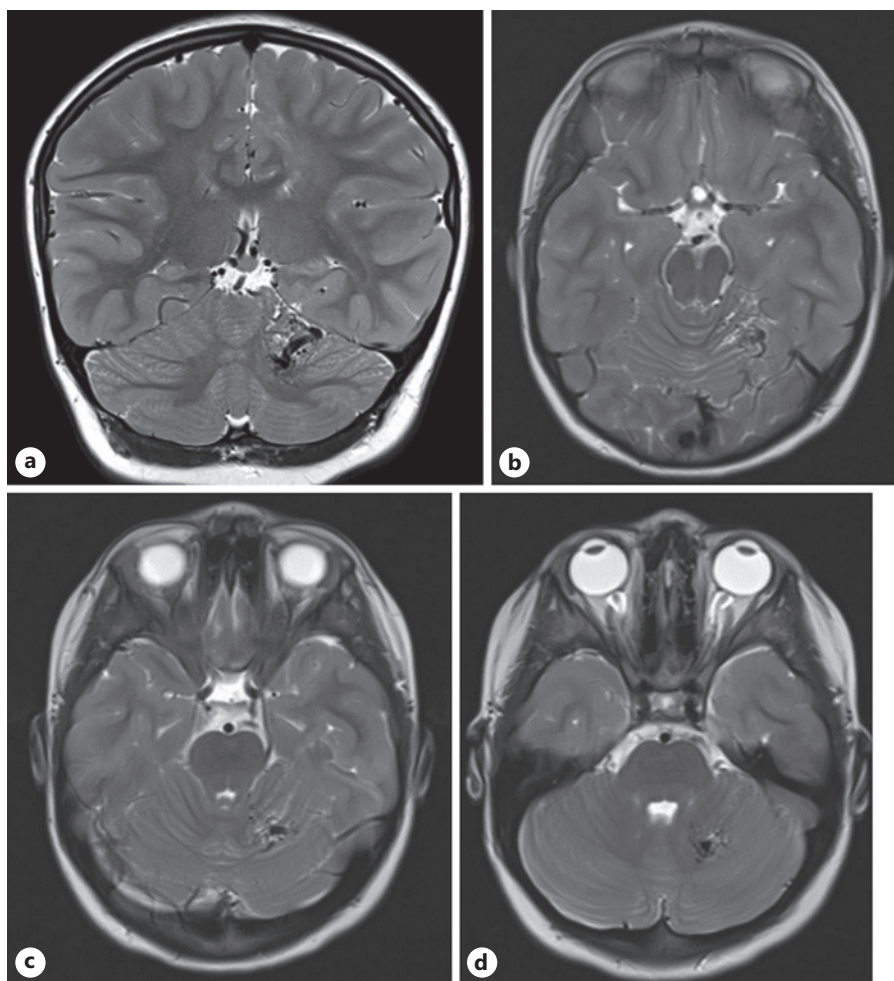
Preoperative multiplanar T2-weighted MRI images demonstrate the left cerebellar AVM nidus with partial involvement of the left dentate nucleus, as well as adjacent dilated draining veins. a Coronal view. b Axial view. c Axial view. d Axial view.
